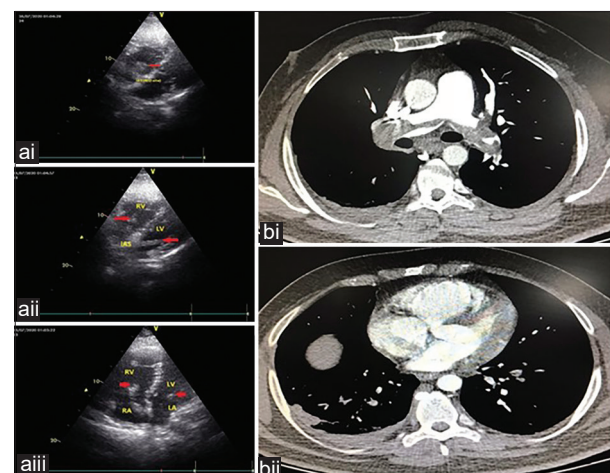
(ai) Subcostal view shows a protruding thrombus burden in left ventricle and right ventricle (arrows) during diastole. (aii) Modified subcostal view focused on inter-arterial septum shows redundant inter-arterial septum with elongated thrombus straddling the inter-arterial septum via patent foramen ovale. (aiii) Apical 4-chamber view demonstrates severe right ventricle and right atrial dilation; McConnell's sign is present, and arrows indicate a large thrombus burden in 4 chambers. (bi) Pulmonary computed tomography angiogram. (bii) A clot in patent foramen ovale
